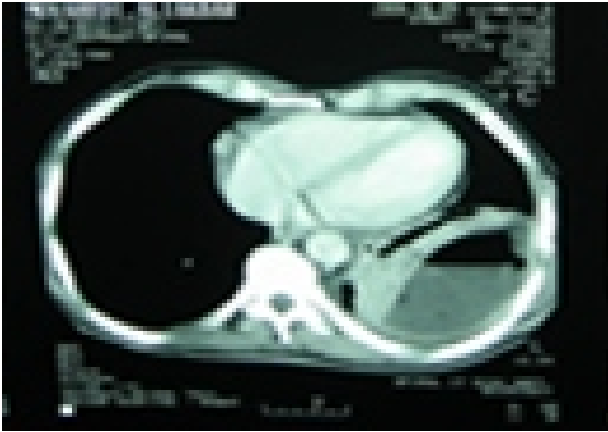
CT-scan, show pleural empyema caused by rupture of pulmonary hydatid cyst in pleural space
